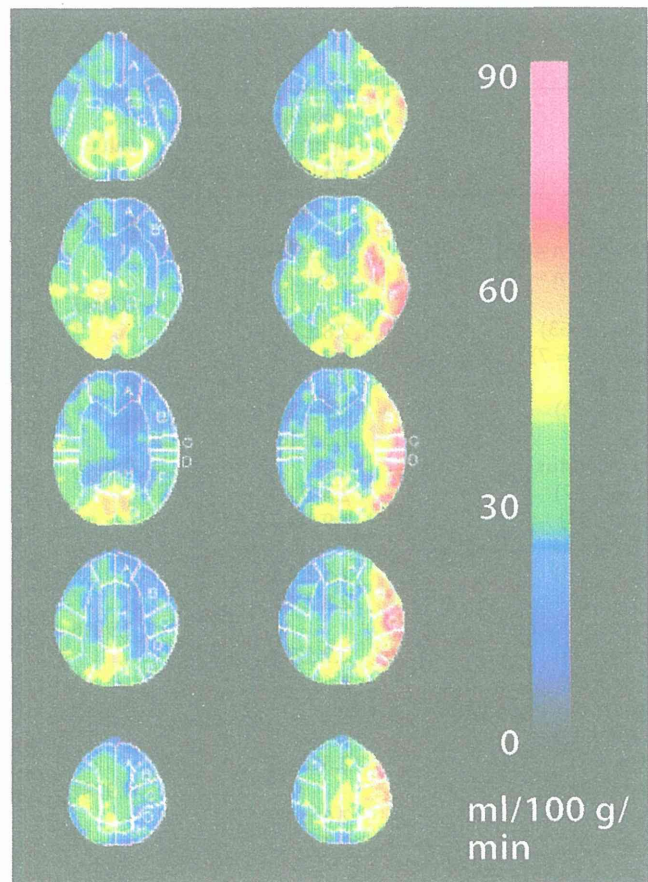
A 73-year-old man with symptomatic left ICA stenosis (90%) exhibiting cerebral hyperperfusion syndrome and cognitive impairment after left CEA. Preoperative brain perfusion SPECT shows reduced blood flow in the left hemisphere (left row) where hyperperfusion develops immediately after surgery (right row).
